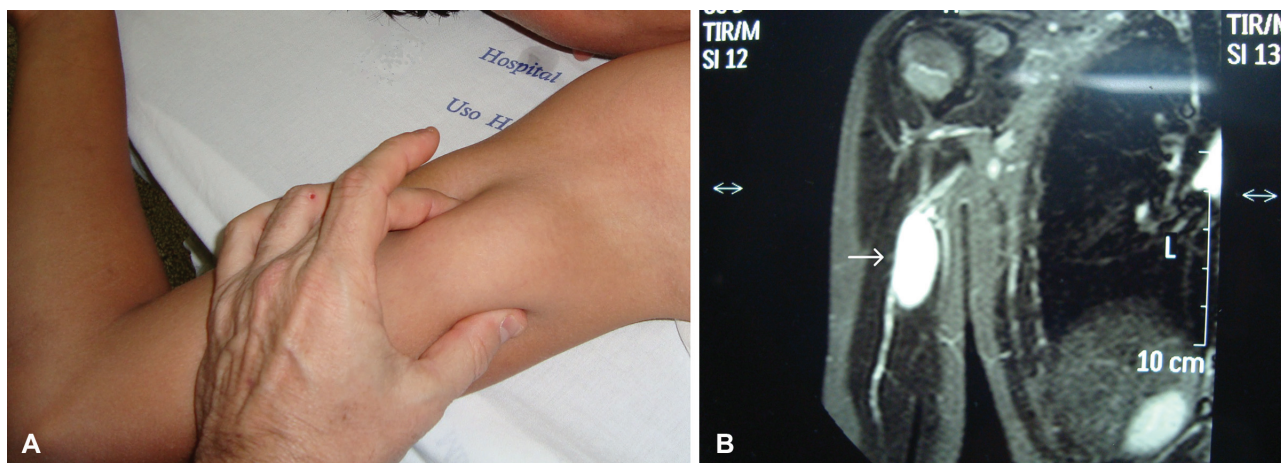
Preoperative photographs of patient number 5, affected by schwannoma in the right arm. (A) Top view of the right arm with tumors in the medial region highlighted by palpation. (B) Photograph of the magnetic resonance imaging scan of the right upper limb with the arrow indicating the schwannoma in the medial cutaneous nerve of arm.
